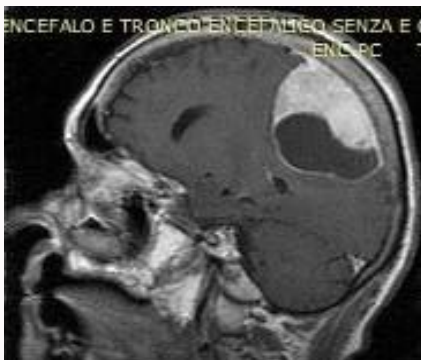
Case 1: MRI Siemens MAGNETOM SKYRA 3-T examination revealed an extra-axial mass adherent to right parieto-occipital convexity dura mater with internal hemorrhagic nodules, suggestive for hemorrhagic meningioma.
